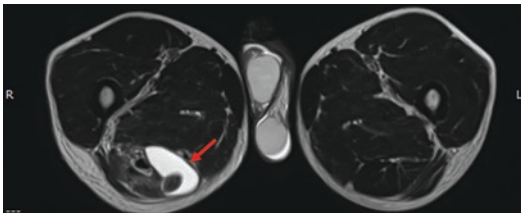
MRI of an avulsion injury with hematoma formation in the ischiocrural muscles of the right lower extremity after acute trauma during heel hook (see arrow)
